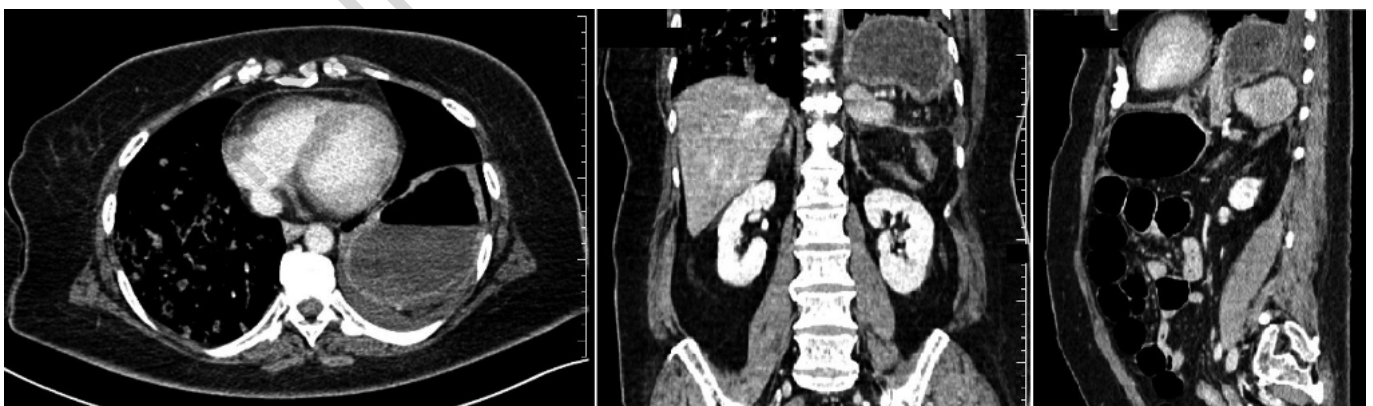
The chest and abdomen CT showed a great hiatal hernia with translocation of the whole stomach and spleen in the rib cage; the stomach also appeared to rotate along its axis with abundant air in the context of the gastric walls of the fund.
